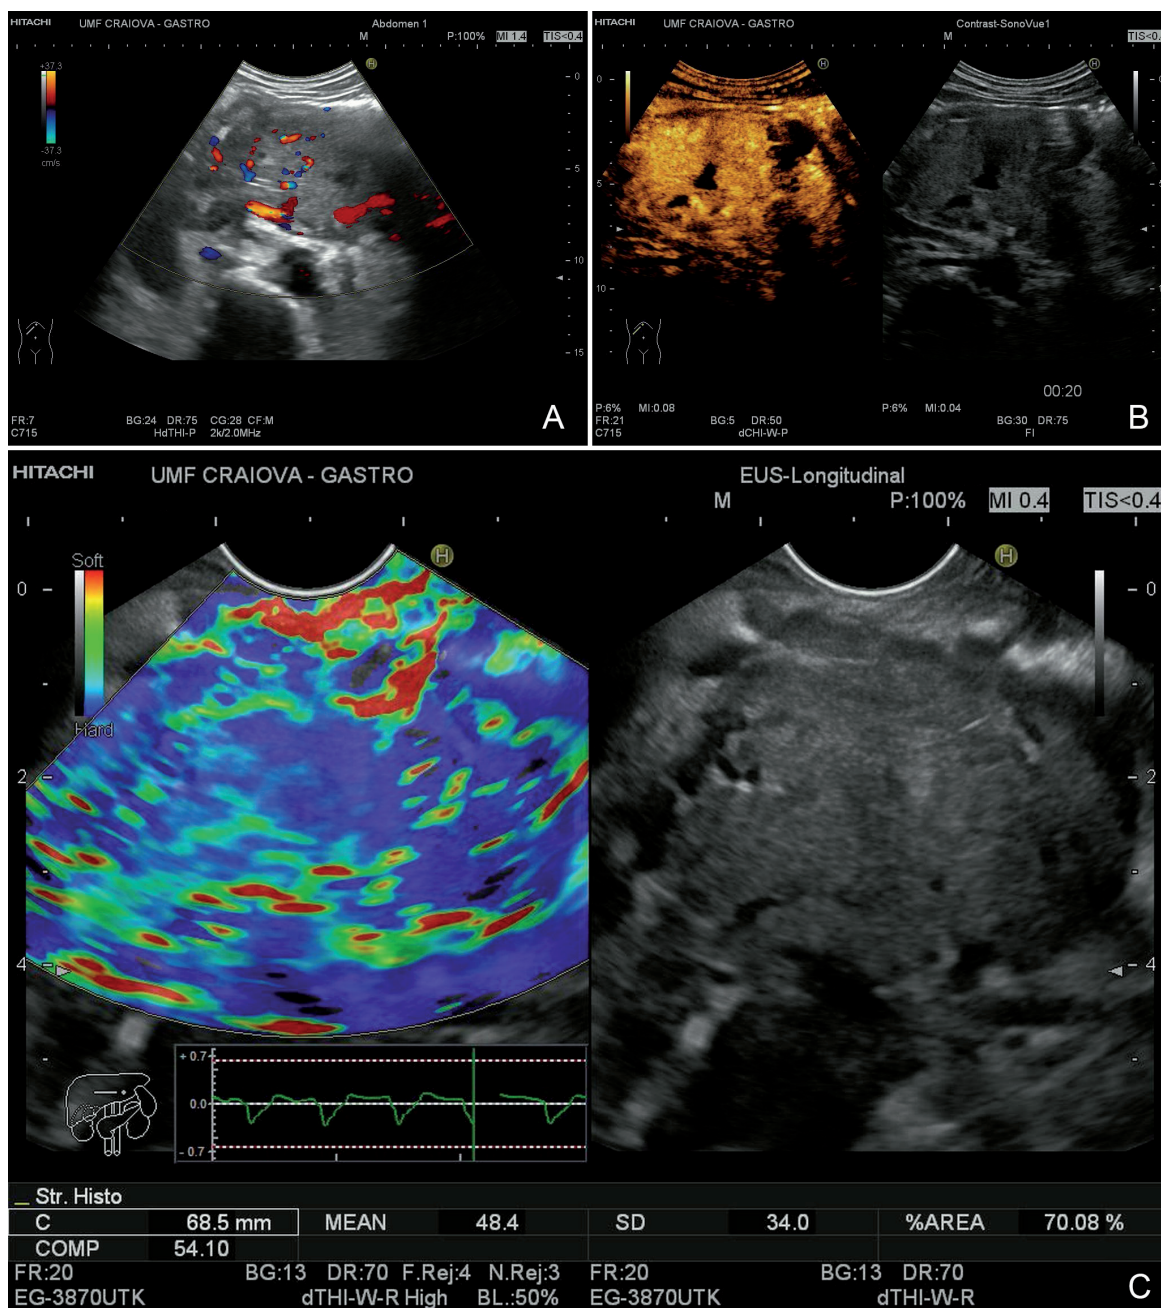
Multimodal imaging of a solid pancreatic tumor, neuroendocrine tumor. A. EUS – Doppler imaging. B Contrast-enhanced ultrasound imaging. C. EUS-E imaging with strain histogram.
